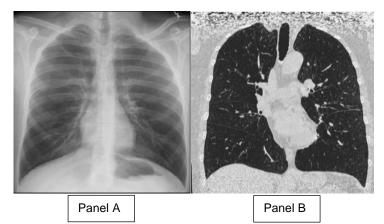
Lungs of a patient diagnosed with chronic obstructive pulmonary disease (COPD). Panel A shows a chest radiograph from a patient diagnosed with COPD. The lung shows hyperinflation, identified as larger lungs in comparison to normal lungs as a result of trapped air. Panel B displays a CT scan of the lungs from a patient diagnosed with COPD. A reduction of the pulmonary perfusion is shown²².
